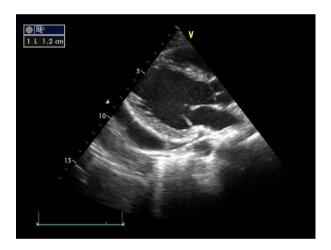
Cardiac ultrasound showing concentric pericardial fluid.
